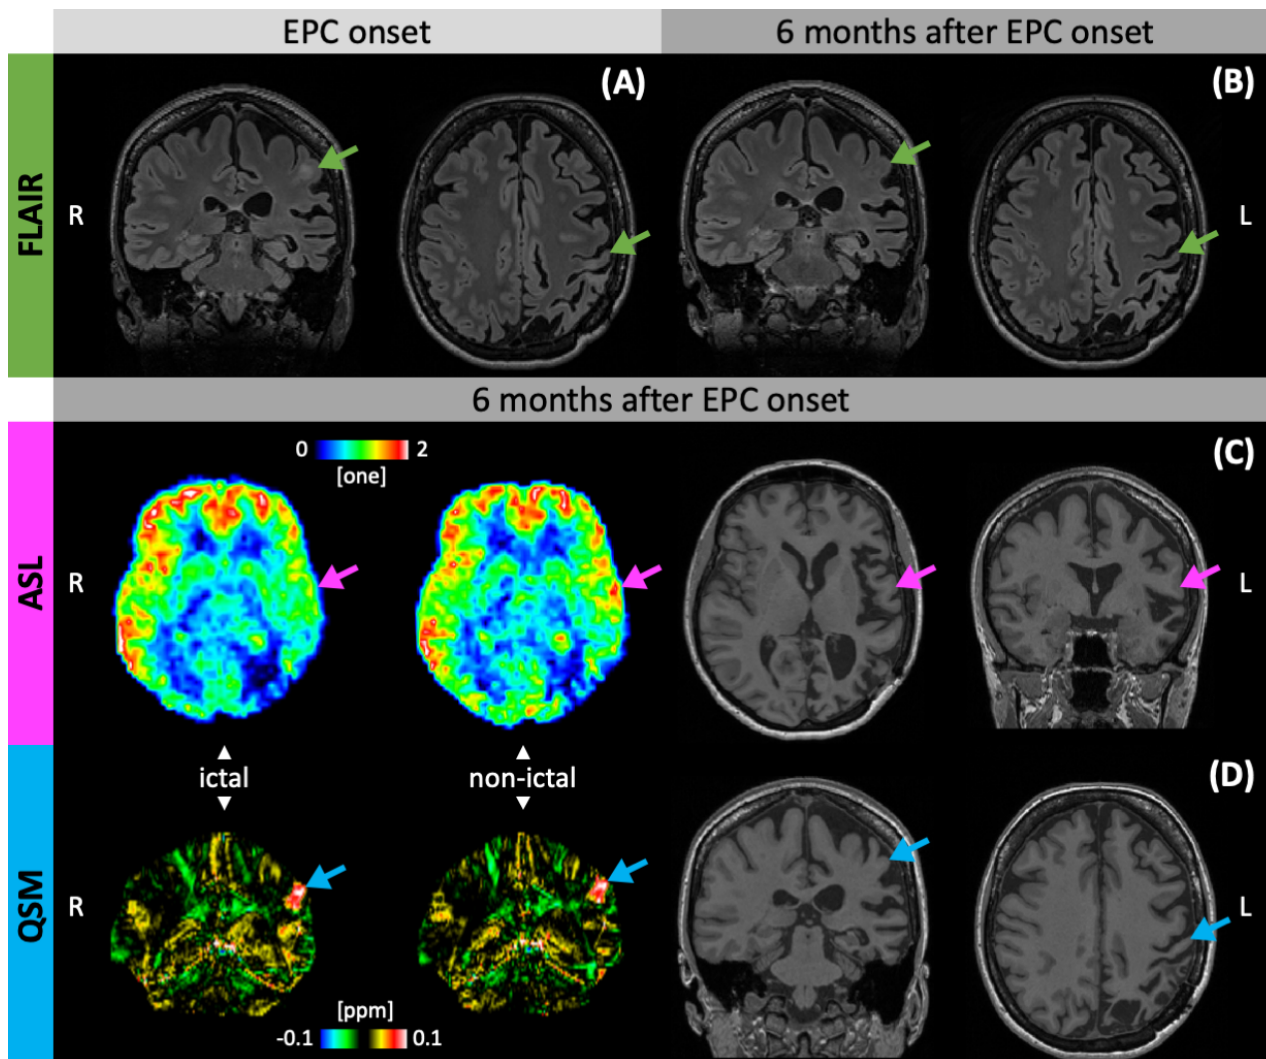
FLAIR images show (A) a hyperintense lesion in the inferolateral postcentral gyrus at the time of epilepsia partialis continua onset, which (B) is no longer visible six months later (green arrow). (C) Mean-gray-matter-normalized arterial spin labeling perfusion values show an ictal hypoperfusion of the lesional and a consistent perfusion of the non-lesional hemisphere between the ictal and non-ictal scan six months after EPC onset. An inferolateral pericentral ictal hypoperfusion is also notable (pink arrow). (D) Quantitative susceptibility mapping (QSM) shows an area of increased susceptibility in the same region in both the ictal and in the non-ictal condition six months after EPC onset (blue arrow).
